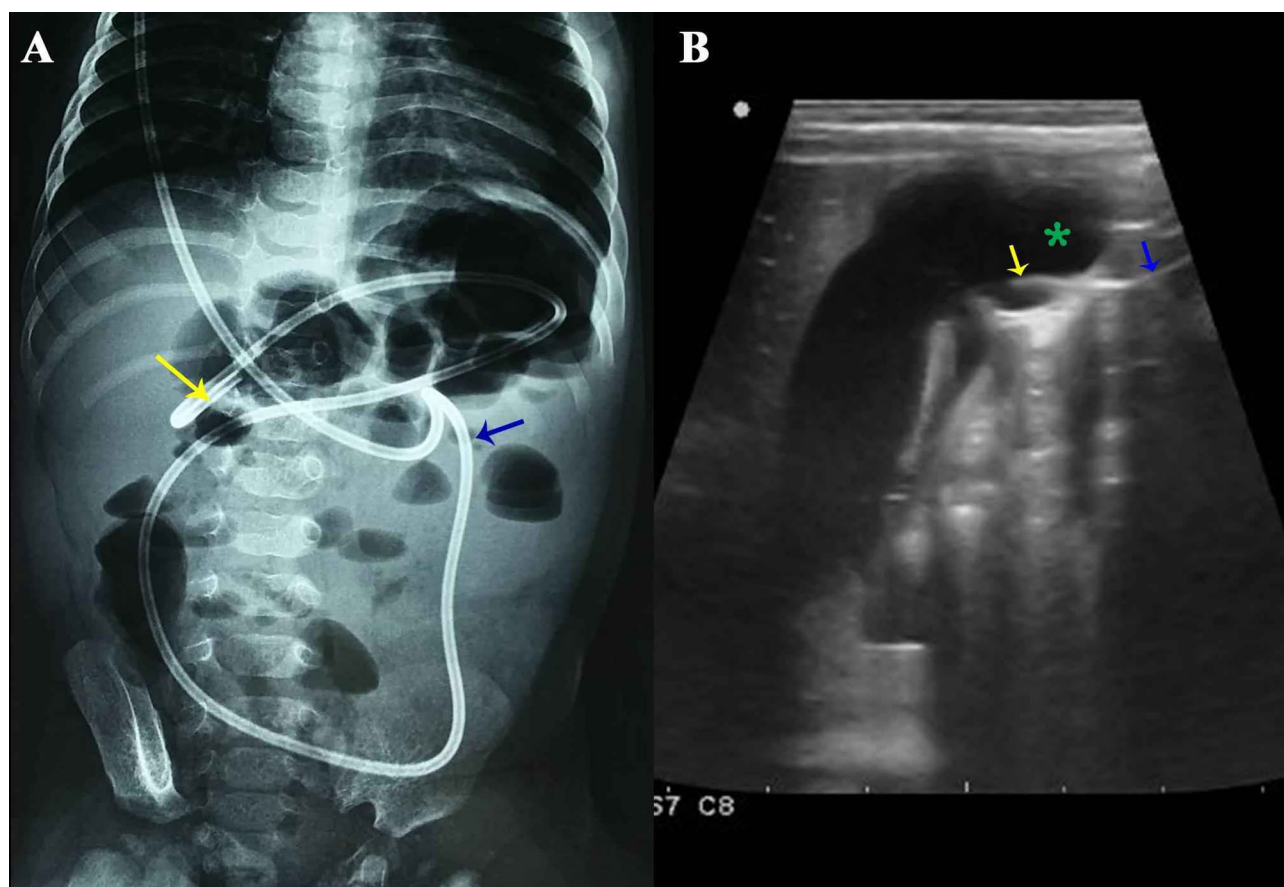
Post-operative imaging X-ray A and ultrasound B showing the tip of the distal catheter (yellow arrow) embedded into the gallbladder (green asterisk) and the intraperitoneal catheter (blue arrow)
